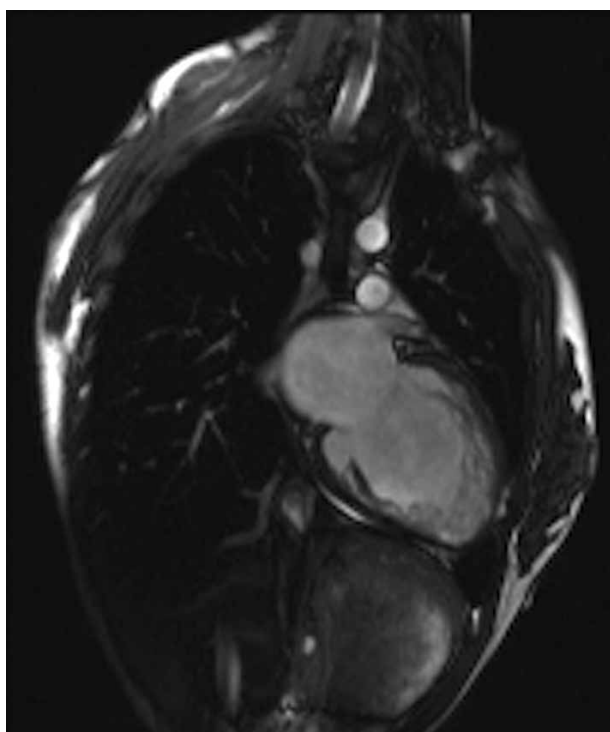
Cardiac magnetic resonance image in a patient with left ventricular non-compaction, cine SSFP sequence. Prominent trabeculations are seen in the left ventricle
